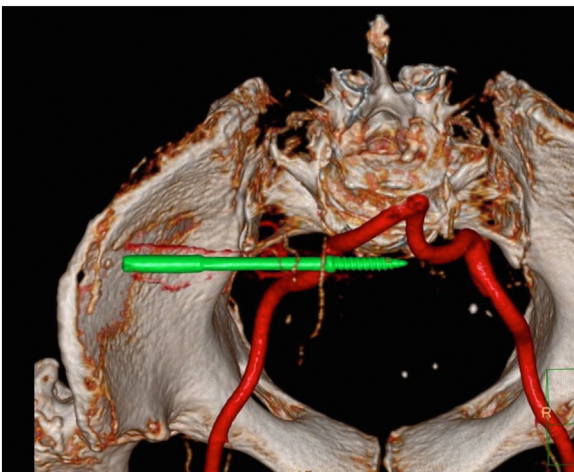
3D reconstruction CT sequence of pelvis within pelvic cavity.
